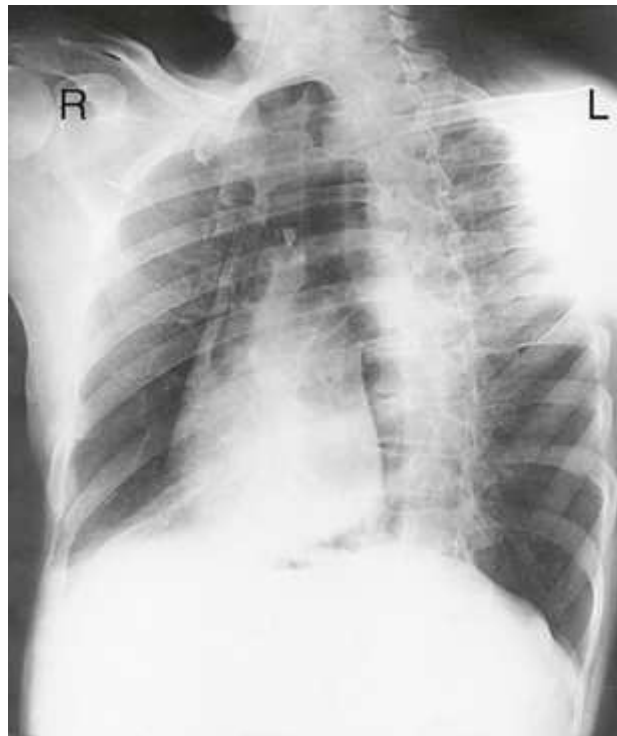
PA oblique chest radiograph is displayed with the anatomy in the anatomic position. The patient's left side is on your right, as though the patient were facing you.
